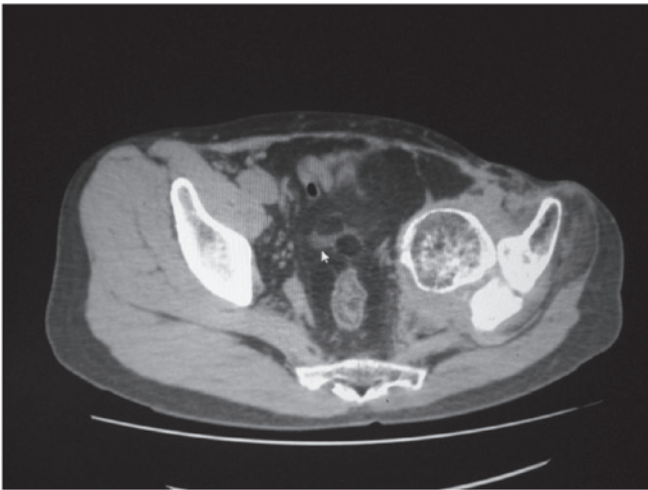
Computed tomography scan revealing osseous resorption and formation, indicating an avascular necrosis-like lesion of the femoral head.
